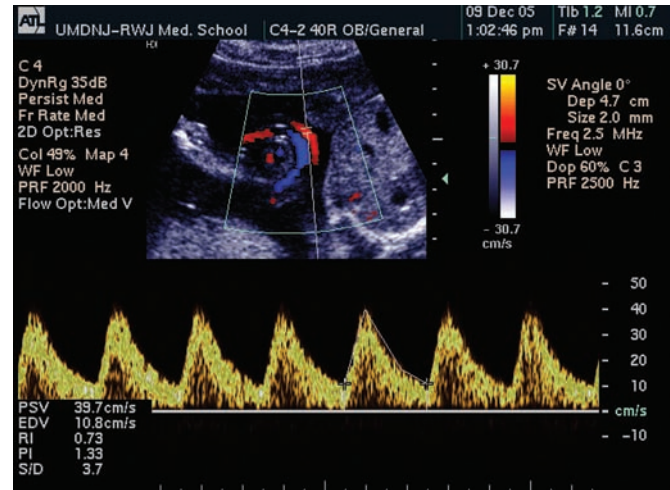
Normal Doppler waveform of umbilical artery in a second-trimester fetus. The systolic/diastolic ratio is 3.7.
